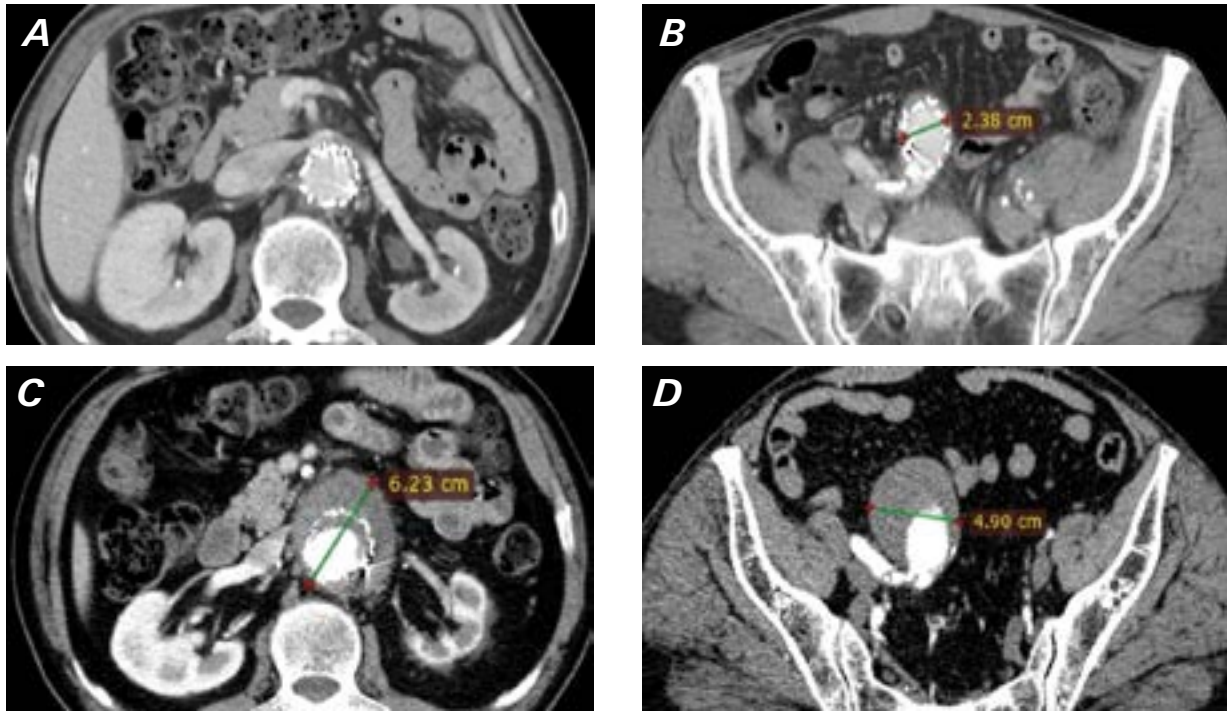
Computed tomographic images obtained after the EVAR procedure 4 years apart. Note that the A) proximal neck and the B) distal right iliac leg of the graft had been properly placed and was in good position immediately after the EVAR procedure. Dilatation and thrombus formation at the C) juxtarenal aortic wall and D) dilatation of the right common iliac artery 4 years later. EVAR, endovascular aortic replacement.
